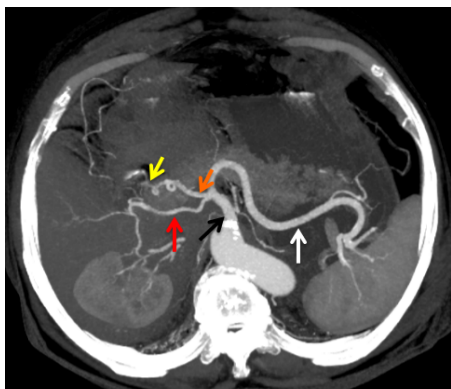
Axial MIP image show replaced RHA (Red arrow) directly originating from CT (Black arrow). LHA (Yellow arrow) is seen originating from CHA (Orange arrow). SA (White arrow).
